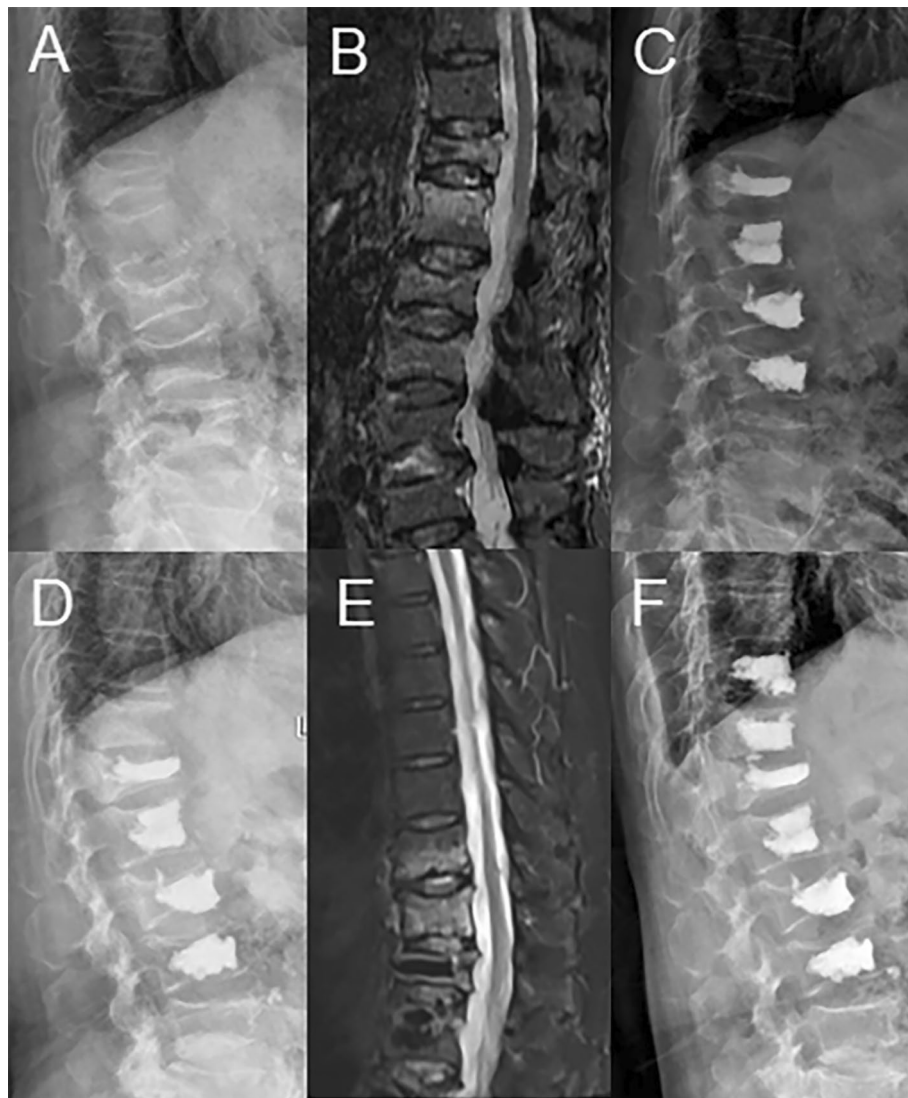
A representative case of AVF after PKP (A-F). (A,B) X-ray and MR images revealing fracture of the T12-L3 vertebrae in a 73-year-old female. (C) X-ray demonstrating that fracture of the T12-L3 vertebrae was treated. (D,E) X-ray and MR images indicating that the T10 and T11 vertebrae fractured two months after surgery. (F) X-ray showing that the fractured T10 and T11 vertebrae were treated again.
